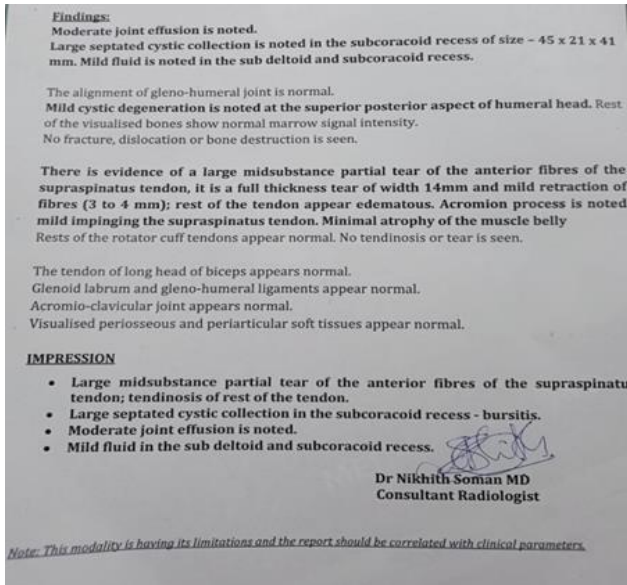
MRI of right shoulder joint.
